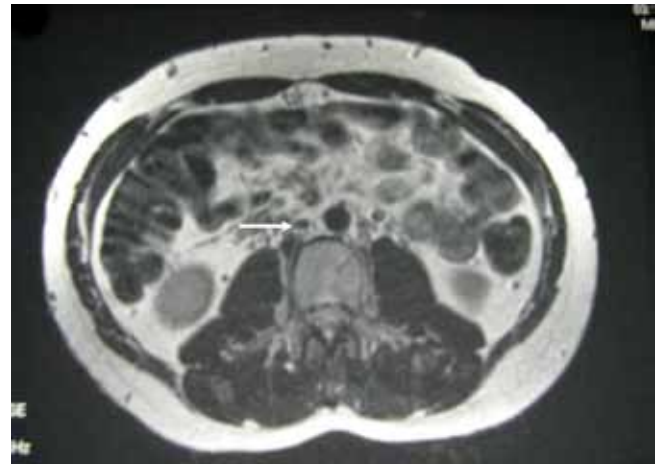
T2-weighted axial MRI demonstrating the mass (predominantly high signal) in the right retroperitoneal space anterior to psoas muscle between the IVC and right kidney (Black Arrow) compressing the overlying IVC (White Arrow).
